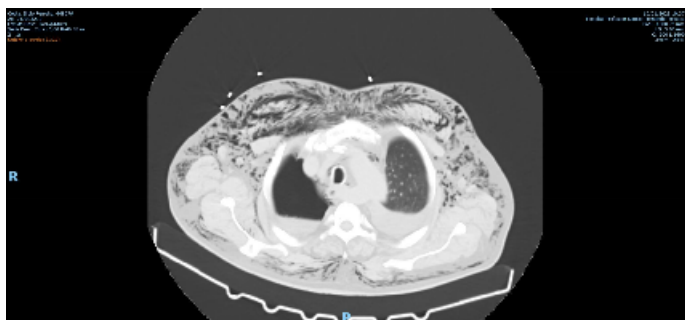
CT-scan showing extensive subcutaneous emphysema and right hydropneumothorax.
